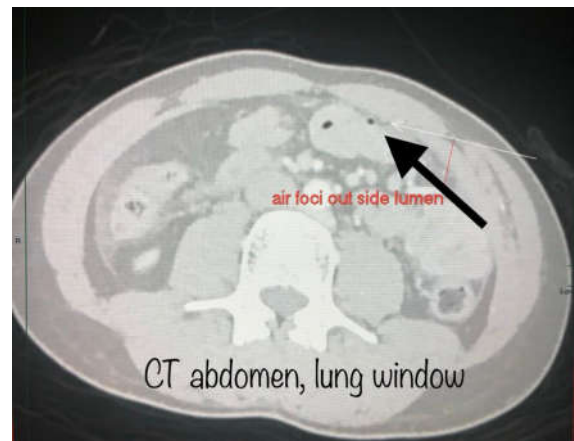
CT scan abdomen showed air foci outside lumen (another cut)
